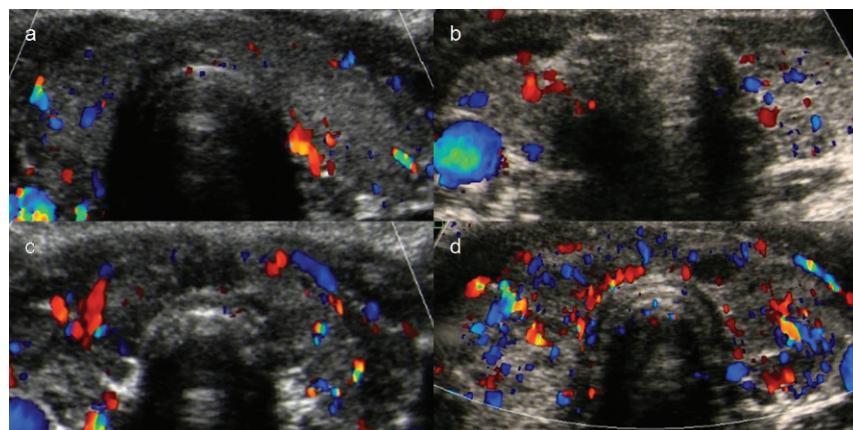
Color Doppler patterns. a. Pattern 0 (normal thyroid vascularity); b. color Doppler Pattern I (minimally increased thyroid vascularity); c. color Doppler Pattern II (increased blood flow with a diffuse homogenous distribution); and d. color Doppler Pattern III ("thyroid inferno").
